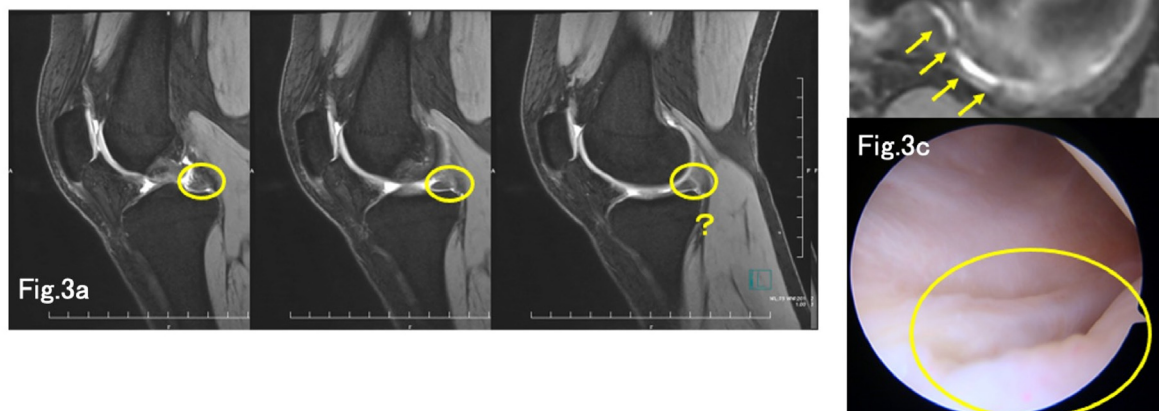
Case 2; 14-year-old female. (a) A magnetic resonance image of a ramp lesion (RL) (arrow) in the sagittal plane. The RL cannot be clearly identified by these planes. (b) An RL (arrow) in the axial plane. The RL can be easily detected in the axial plane. (c) Intraoperative left knee meniscal ramp lesion (circle) around the medial posterior horn of this case.
